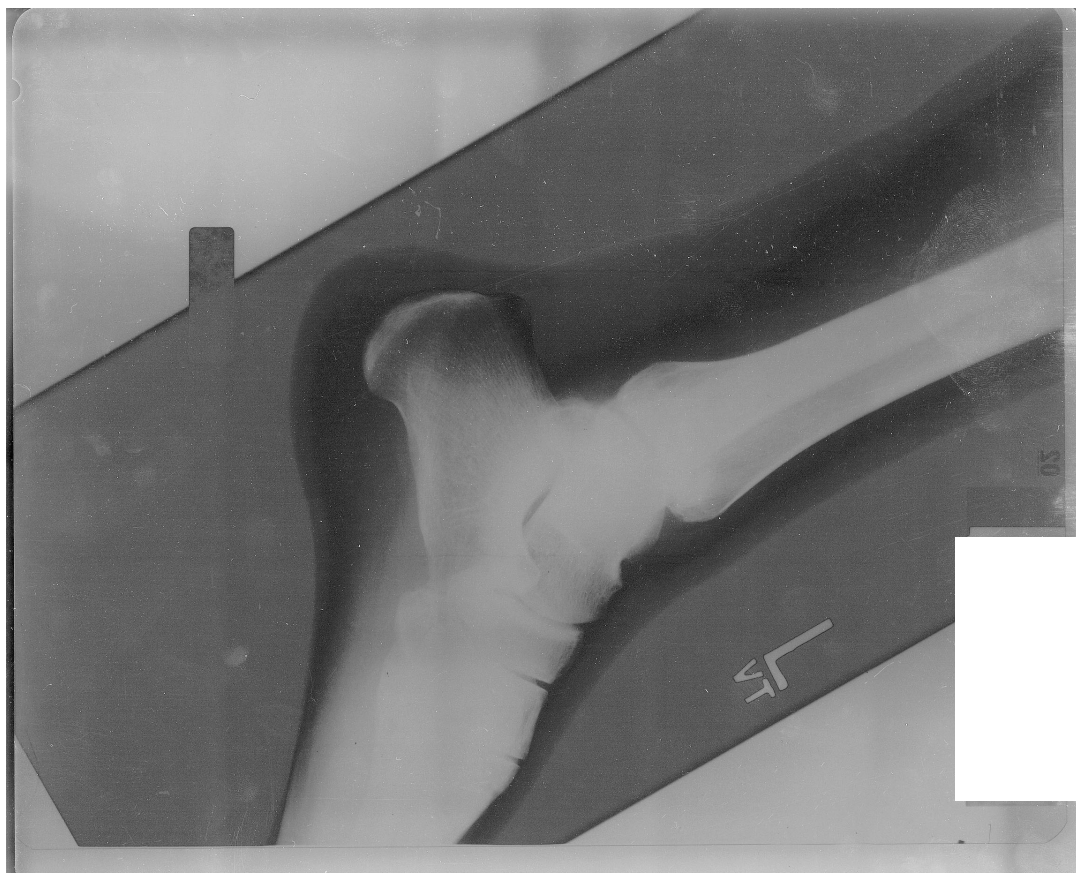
Radiographs from PWC File 22.
